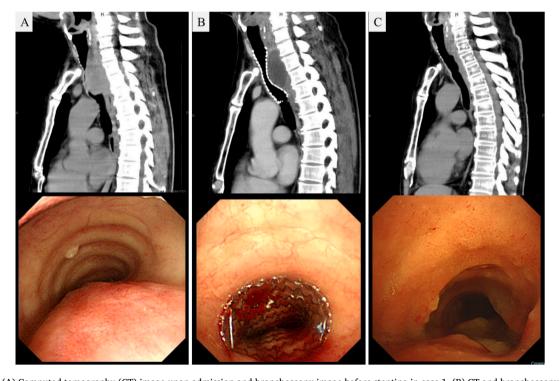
(A) Computed tomography (CT) image upon admission and bronchoscopy image before stenting in case 1. (B) CT and bronchoscopy images after stenting. (C) CT and bronchoscopy images after stent removal.
